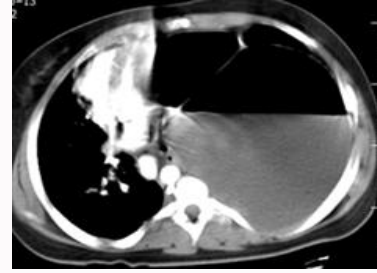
CT-scan of chest show large air fluid level with sever shift of mediasinum and collapse of left and right lung.
